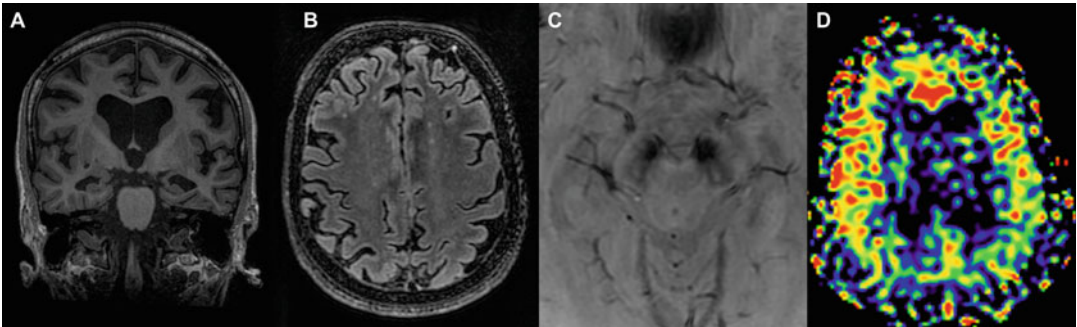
76-year-old woman with moderate AD symptomatology. Para-coronal (along the axis of the temporal lobe) reformatted T1w (a), axial reformatted 3D T2w FLAIR (b), zoom of axial susceptibility imaging (c), and axial ASL (d)
